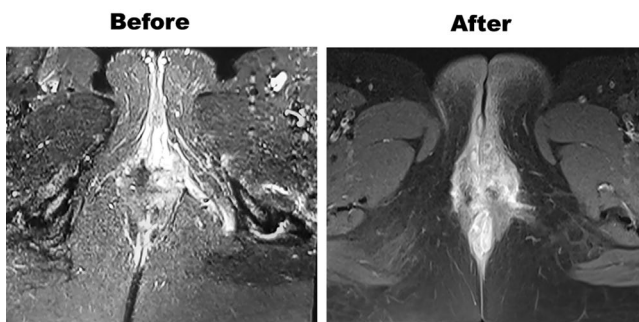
Short inversion recovery and T1-weighted, fat-suppressed (STIR T1W-FS) sequence with contrast injection of axial pelvic images before and after three weeks. Injection of mesenchymal stromal cells (MSCs) showed fistula tract closure on the left side at the 2 o'clock position of the anus. Decreased enhancement and shortening of the fistula tract with clinically reduced discharge was observed after treatment with MSCs.
